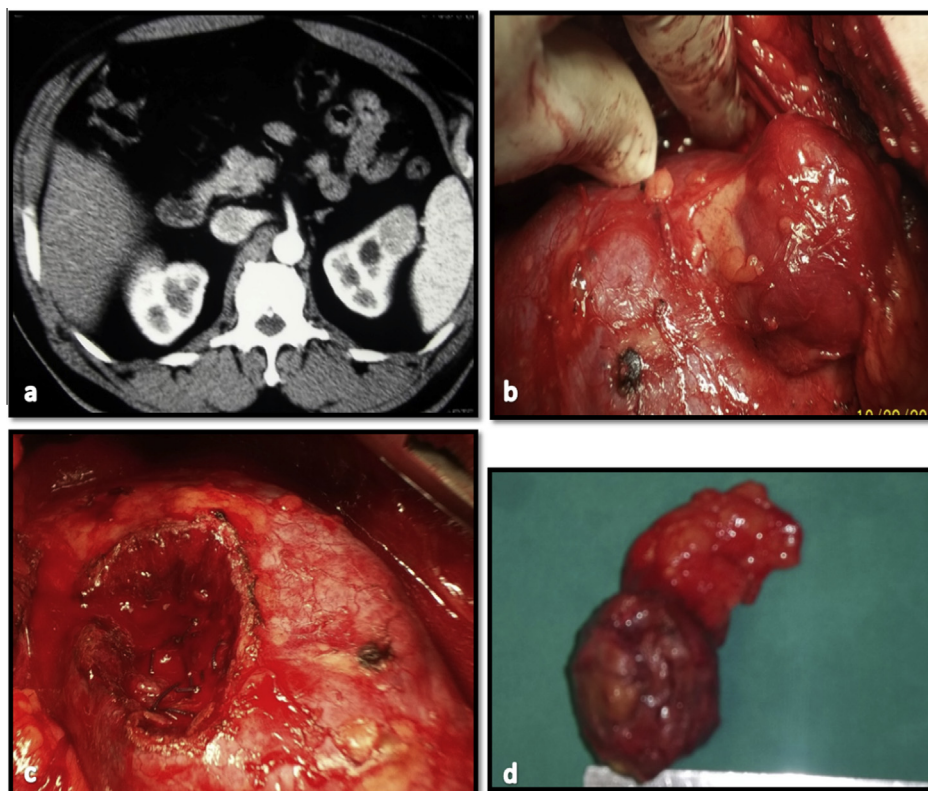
Axial CT image of a left renal exophytic renal mass (a) and the corresponding intraoperative pictures before (b) and after (c) resection of the mass. Picture of the mass after resection (d).
